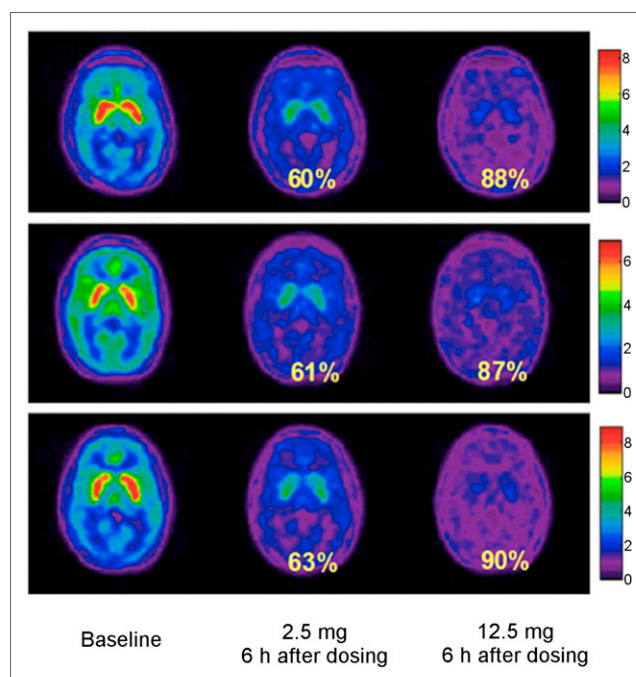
Transverse images at level of striatum for 3 consecutive healthy volunteers, showing RO changes for MK-0249 with 2.5- and 12.5-mg administration, 6 h postdose. Color scale indicates SUVs.
